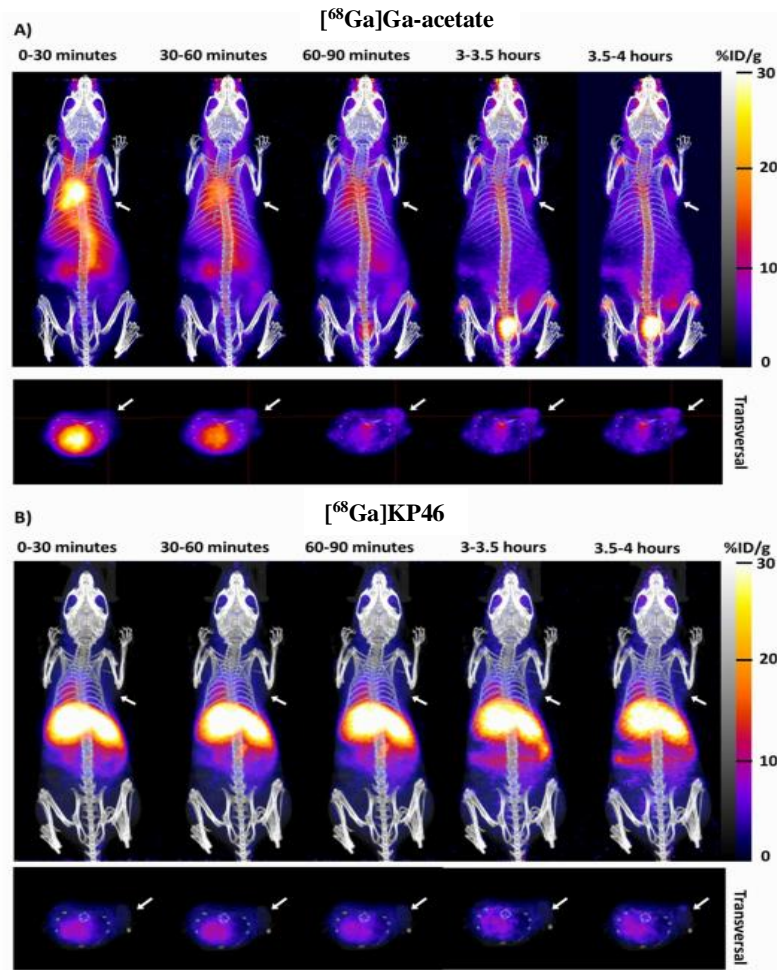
Dynamic MIP PET/CT images of $[^{68}\text{Ga}]\text{Ga-acetate}$ (A), and $[^{68}\text{Ga}]\text{KP46}$ (B) at different time points post i.v. injection. For each image panel, MIP's are shown in the upper part of the image and transverse section images (axial) are showing in the lower part of the image. The white arrow represents the position of the tumour. Captured with permission from C. Imberti thesis (unpublished work).
